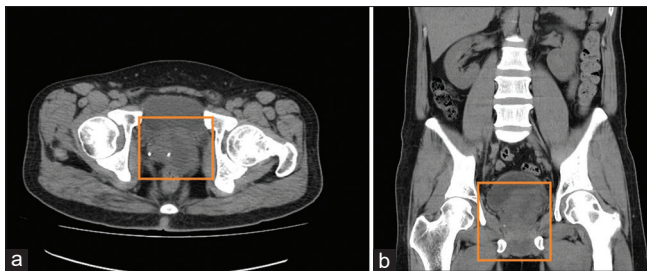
Computed tomography. A computed tomography image reveals prostate enlargement with calcification and heterogeneous enhancement rule out abscess and prostate cancer. (a) transverse view and (b) coronal view
